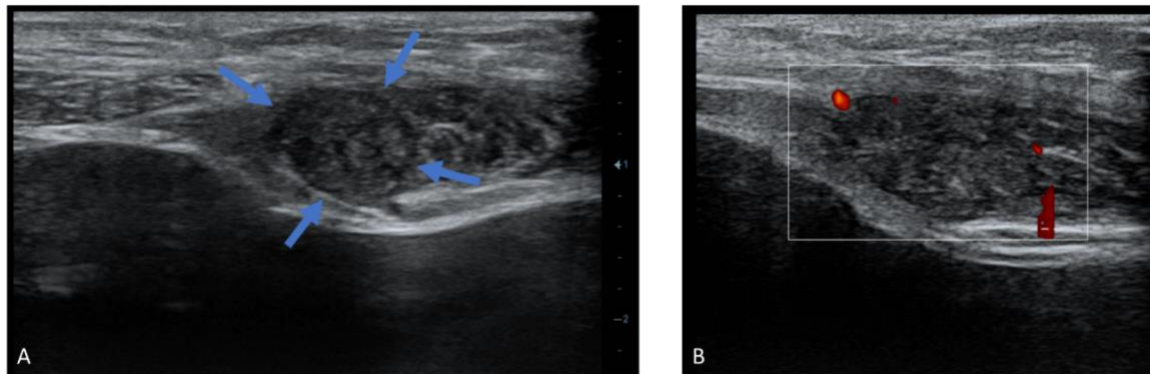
Targeted ultrasonography of the left rectus abdominis lesion. (A) Transverse high-frequency ultrasound demonstrates a well-defined, oval, predominantly hypoechoic lesion (arrows) centered within the left rectus abdominis muscle. (B) Color Doppler ultrasound demonstrates peripheral vascularity surrounding the lesion.
